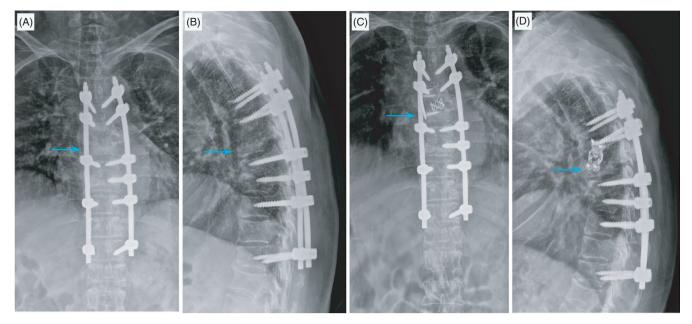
Preoperative and postoperative X-ray examinations conducted during the third surgery in February 2021. (A) The arrow points to the preoperative T6 focal vertebral body in the coronal plane. (B) The arrow points to the preoperative T6 focal vertebral body in the sagittal plane. (C) The arrow points to the postoperative T6 focal vertebral body in the sagittal plane. (D) The arrow points to the postoperative T6 focal vertebral body in the sagittal plane.
